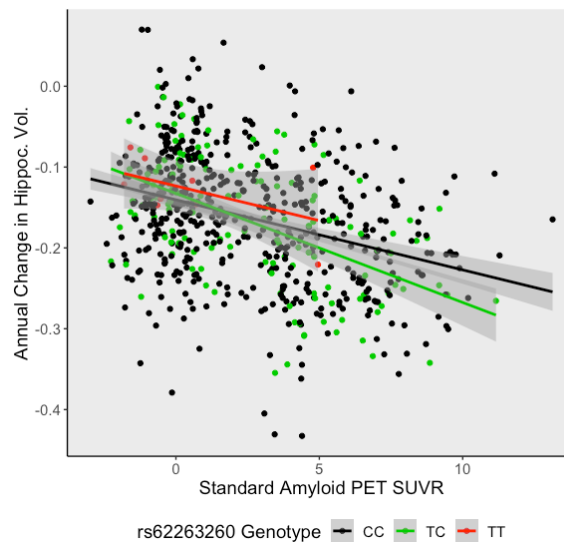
A plot demonstrating how the index SNP, rs62263260, modifies the association between standardized baseline PET amyloid levels and hippocampal atrophy in ADNI. The y-axis represents baseline standardized hippocampal volume, and the x-axis represents standardized amyloid PET SUVR. Points and lines are color coded by genotype, where rs62263260-T heterozygotes are denoted by the green line and homozygotes (TT) are red.
